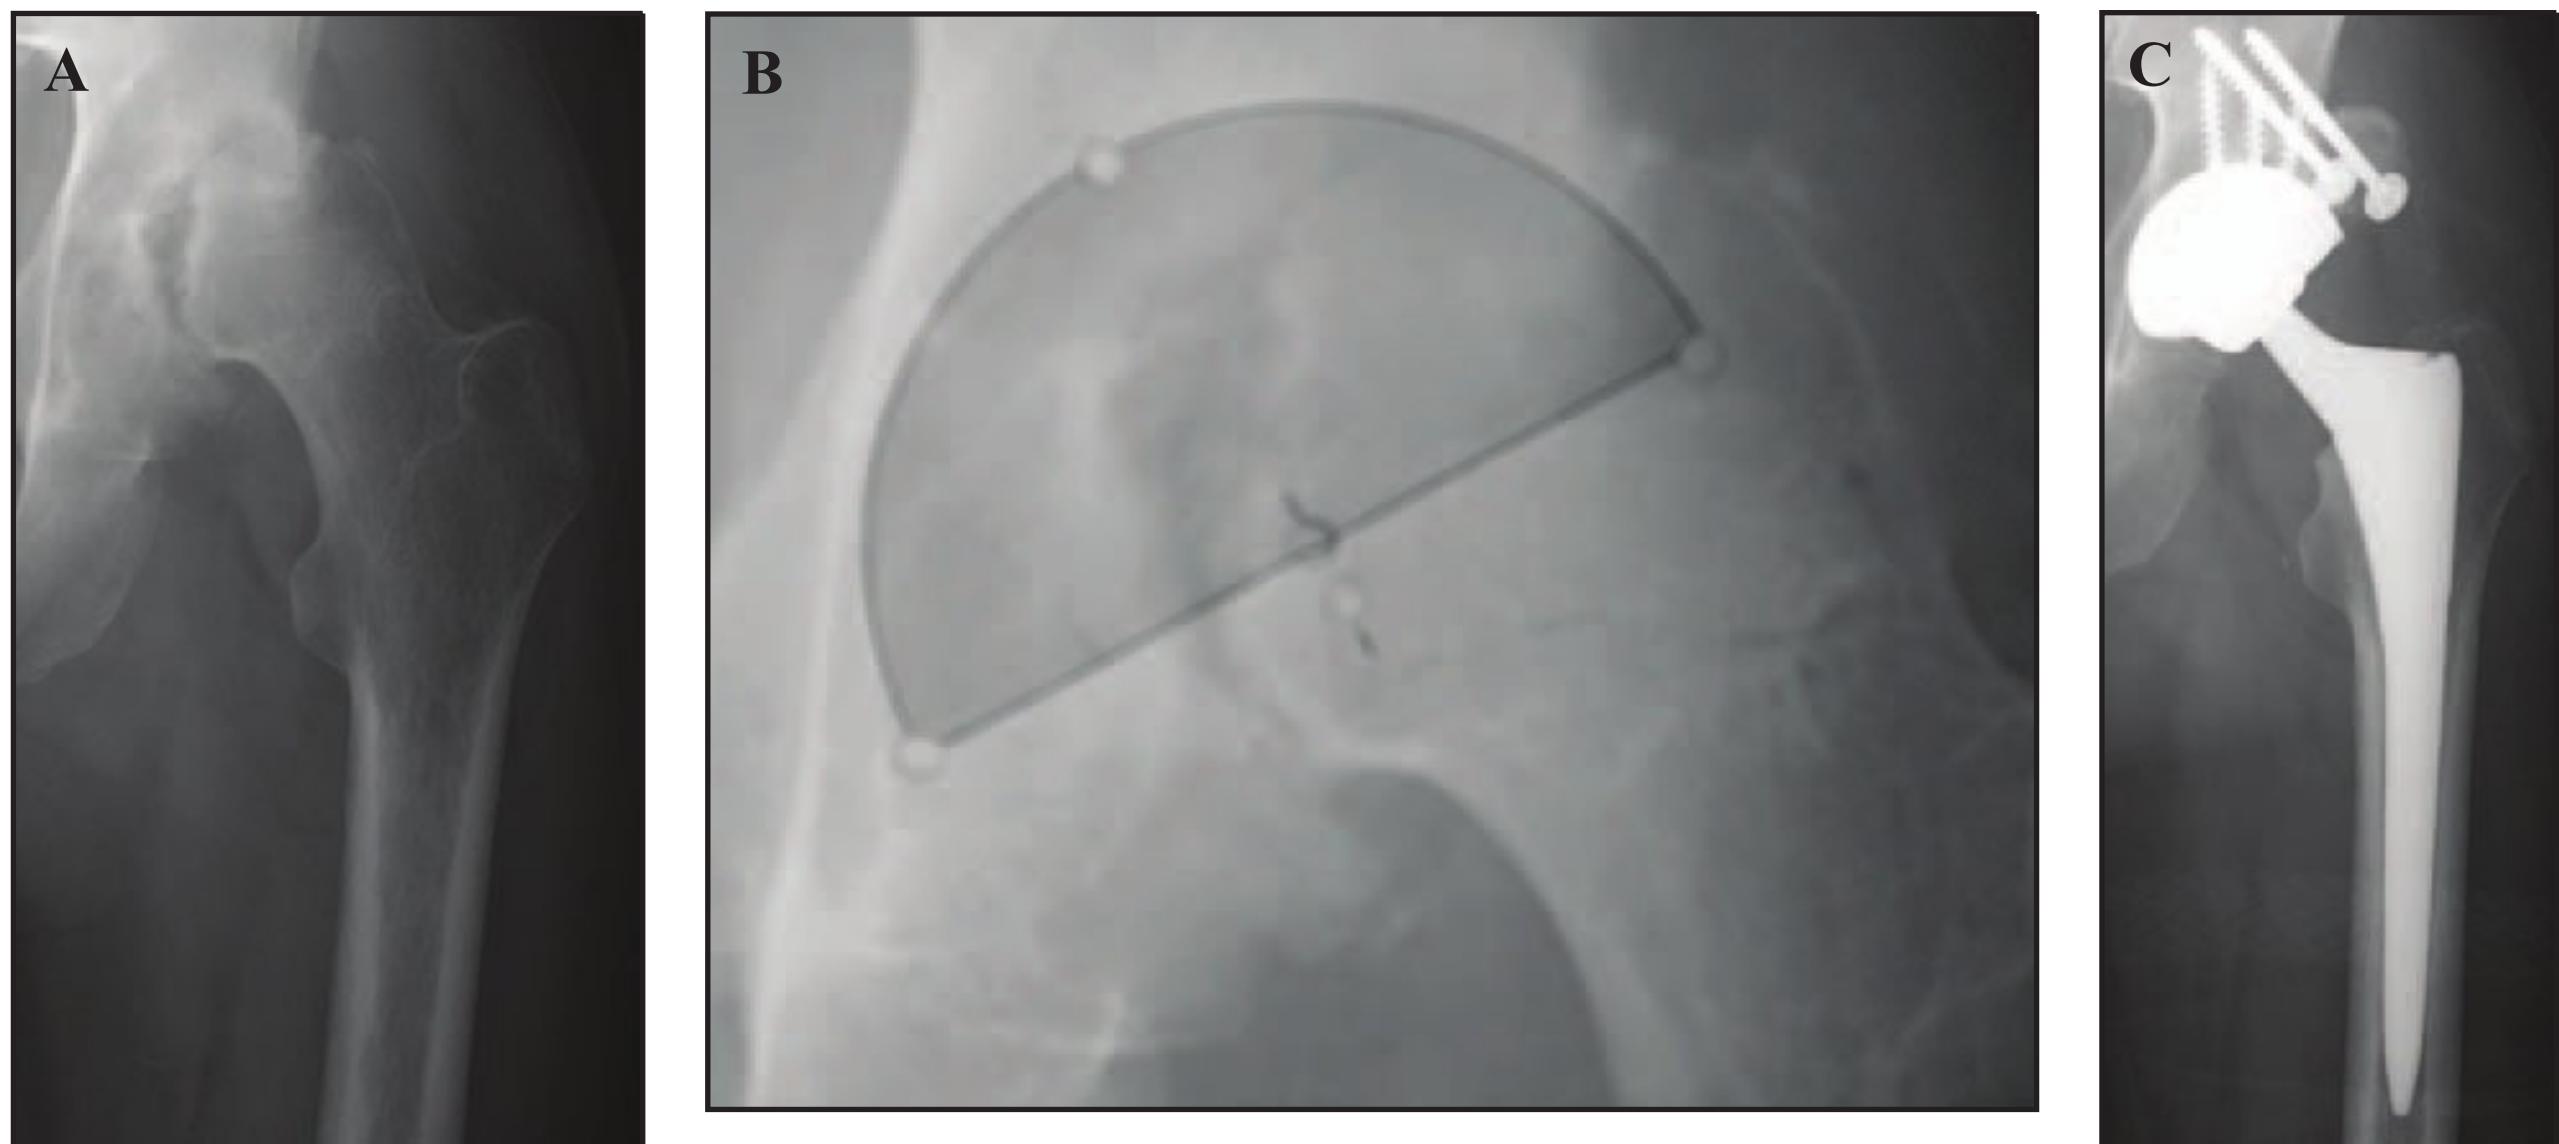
(A) AP radiograph of patient with a history of prior hip fracture dislocation with post-traumatic osteoarthritis and hip subluxation. (B) Preoperative templating demonstrated that greater than 20% to 30% of the acetabular shell would most likely remain uncovered after appropriate placement. This was confirmed following intraoperative reaming and trial insertion. (C) The acetabular component was subsequently augmented with structural femoral head autograft.
